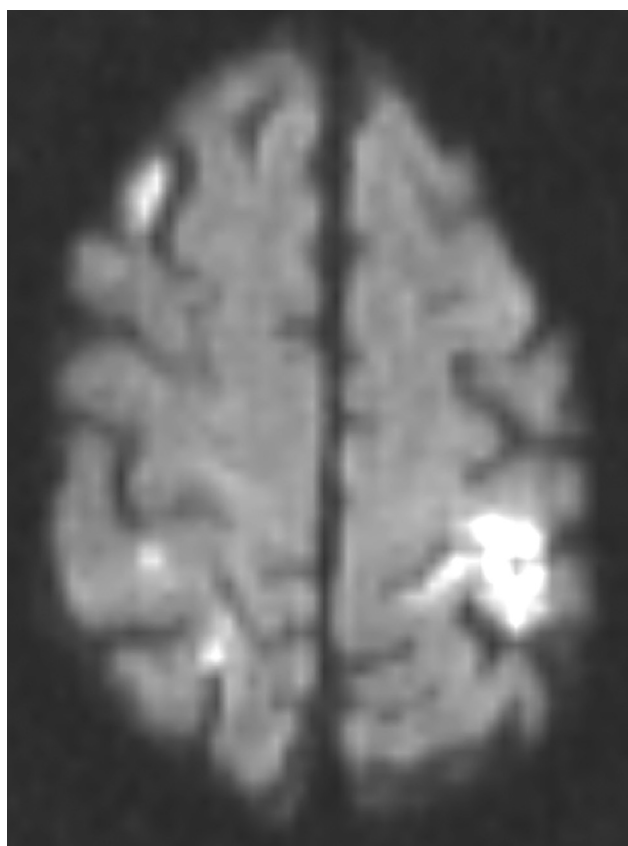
MRI scan of the brain showing the presence of bilateral focal infarcts affecting the left precentral gyrus.
